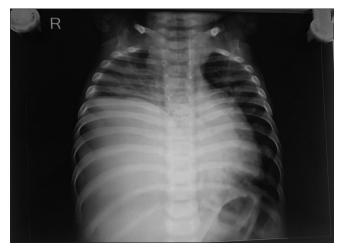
Chest X-ray showing elevation of the right diaphragm with compressive atelectasis of right lung
